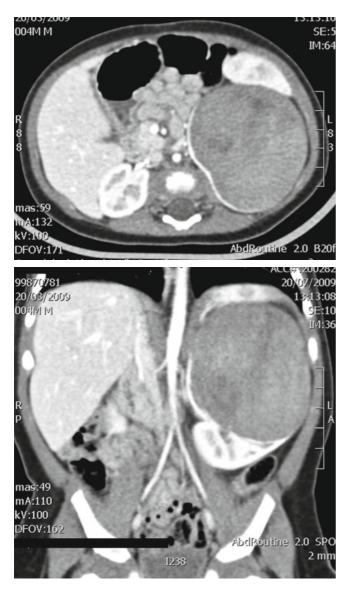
CT imaging of Wilms' tumor with huge solid mass of left kidney
